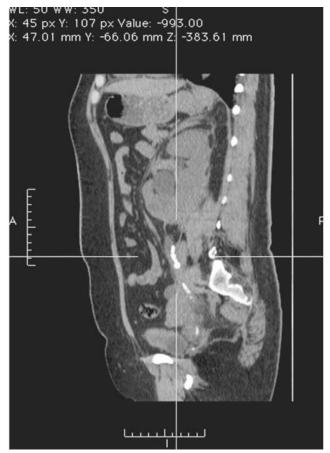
Preoperative CT stonogram showing left hydronephrosis with perinephric hematoma and multiple ureteral stones occupying the left proximal, middle and distal ureteral segments.
